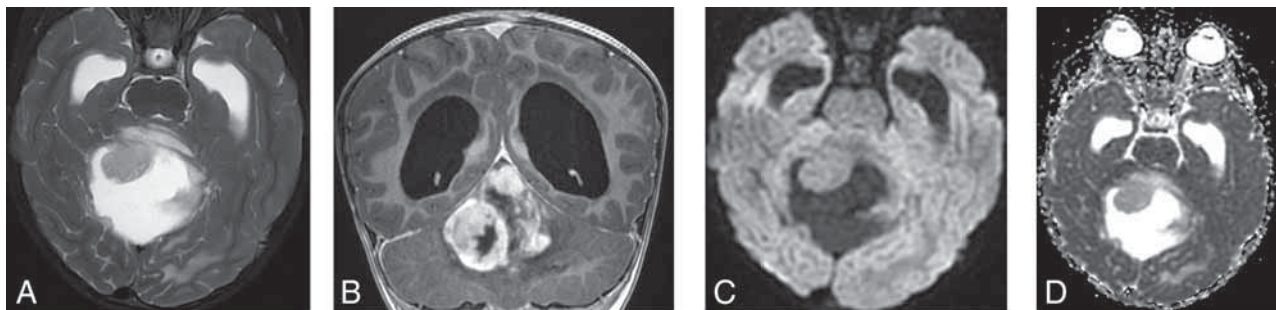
A 3-year-old girl who presented with symptoms related to increased intracranial pressure. The brain MR imaging shows a large complex cystic/solid mass lesion arising from the vermis and anteriorly compressing the fourth ventricle, therefore causing supratentorial massive hydrocephalus. The solid component of the tumor shows slight hyperintense signal on T2WI (A) and diffuse enhancement (B) but not with diffusion restriction (C and D). The tissue diagnosis was pilocytic astrocytoma with KIAA1549:BRAF fusion.
